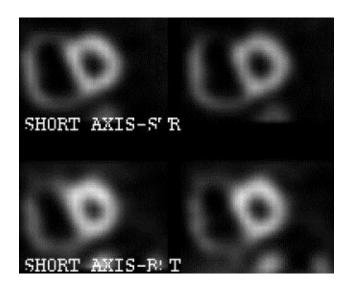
Flattening of the septum seen in short axis view with right ventricular enlargement on the gated SPECT imaging in a patient with systolic pulmonary arterial pressure of 52 mm Hg and history of COPD and atrial septal defect
